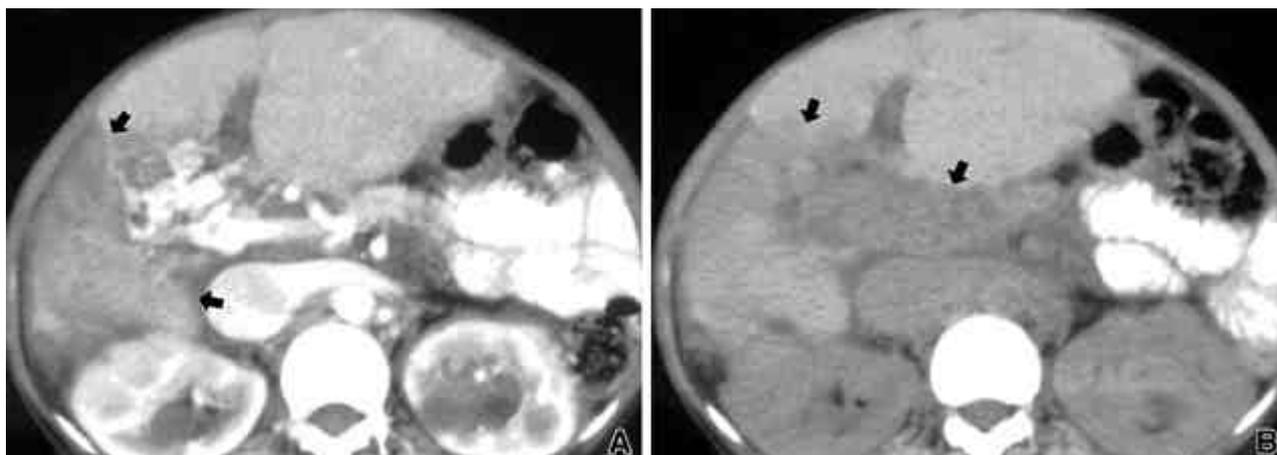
A: Unenhanced CT scan of liver shows large, ill-defined low-attenuation lesion with focal surface retraction in right lobe of liver (arrows). B: Enhanced CT scans at the same level to A shows patchy enhancement of previous lesion (arrows).
